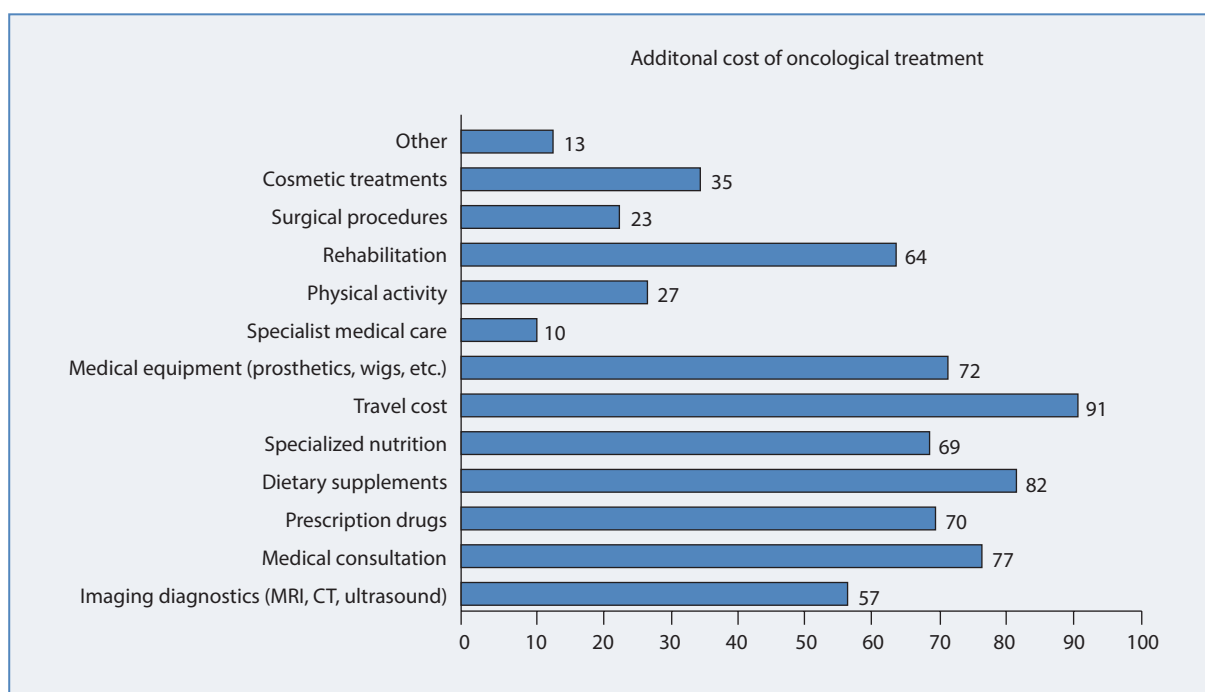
Additional costs of treatment and therapy support; CT — computed tomography; MRI — magnetic resonance imaging
